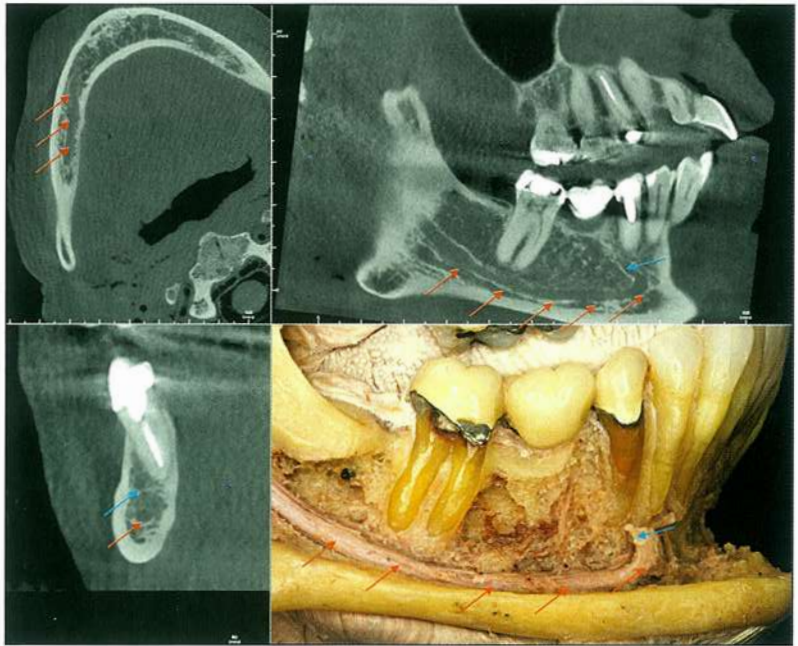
The mandibular canal shown in MPR CBCT reconstruction as well as dissection. The *red arrows* show the course of the canal and nerve. In this case, the canal loops in the anterior region (*blue arrow*). This looping must be considered for surgical treatments in this area.
